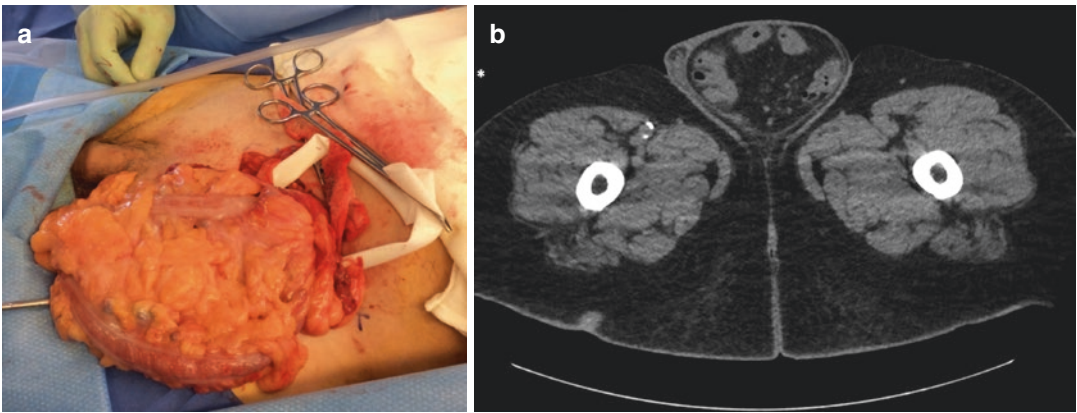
(a) 73-year-old male with left incarcerated inguinal hernia containing sigmoid colon. (b) CT scan of the same patient with incarcerated sigmoid colon in scrotum (*)
